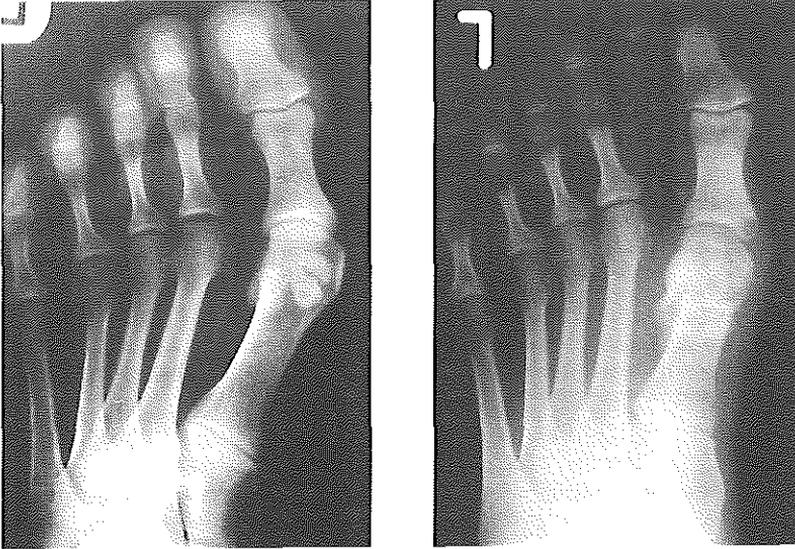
App.4. Examples of non weight-bearing AP radiographs made before (left) and after a modified Hohmann osteotomy (right).
